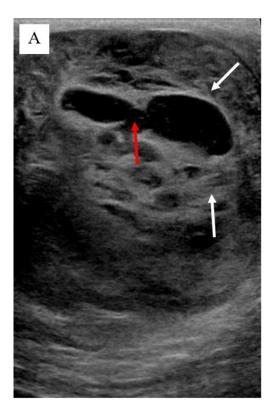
Longitudinal (A) and transverse (B) ultrasound image through the scrotum shows an extratesticular mass (white arrows) and areas of central necrosis (red arrows).
